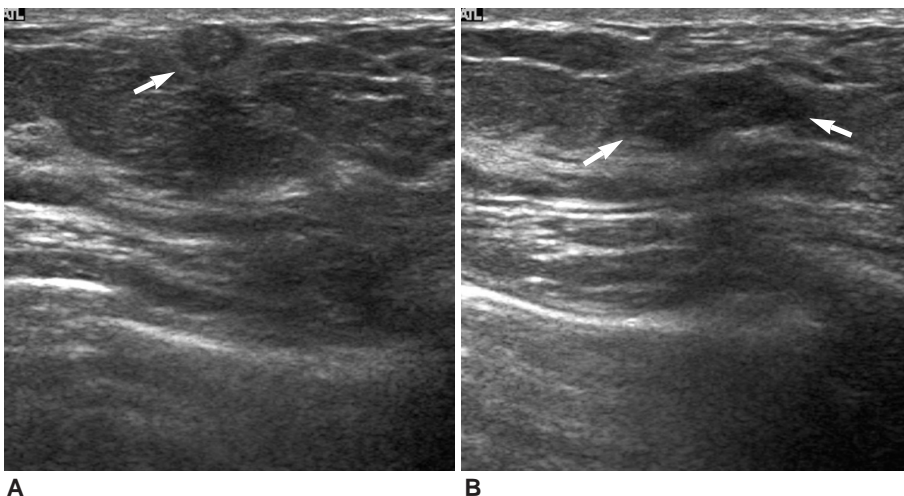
A. Transverse sonogram of palpable mass shows an about 5mm-sized, circumscribed oval hypoechoic nodule (arrow) in 2 o'clock position of the left breast.
